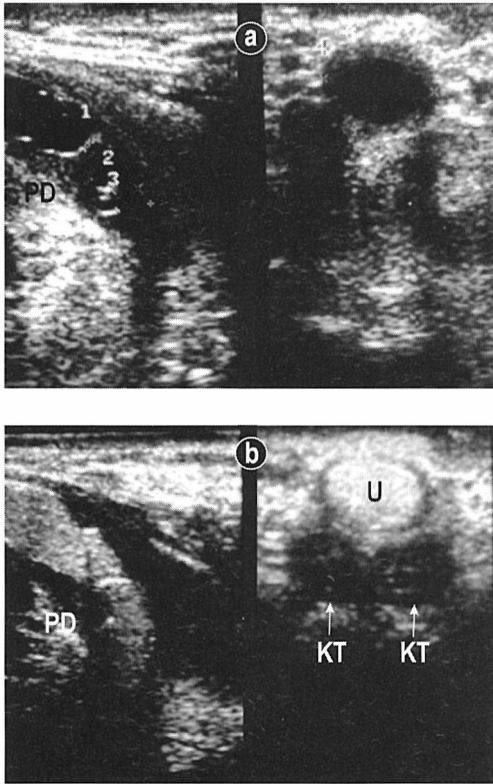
Sonographic urethrography(SUG)- longitudinal and transversal scans; a) Application of saline solution, b) Application of sonographic contrast Levovist. U-urethral lumen, PD-dorsal periurethral fibrosis, KT-corpus cavernosus.
